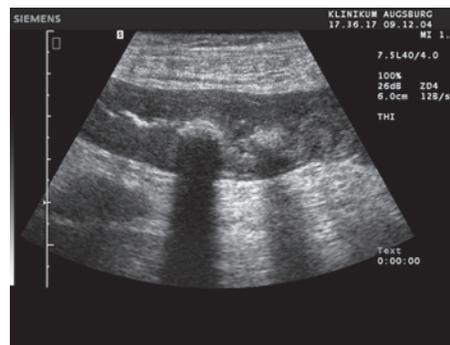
Thickened intestinal wall in the sigmoid colon. Ultrasound examination of the left lower abdomen.
